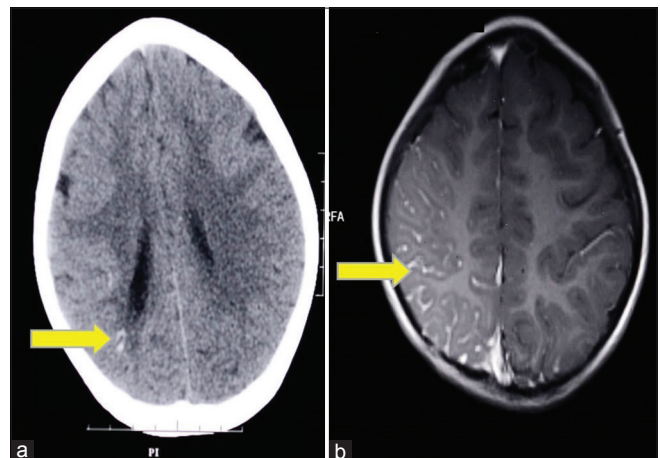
Computed tomography brain shows tram-track calcification in the right parieto-occipital region (arrow, a) and T1-weighted postcontrast magnetic resonance imaging image showing pial angiomas (arrows, b) in parieto-occipital region, predominantly involving the right hemisphere
